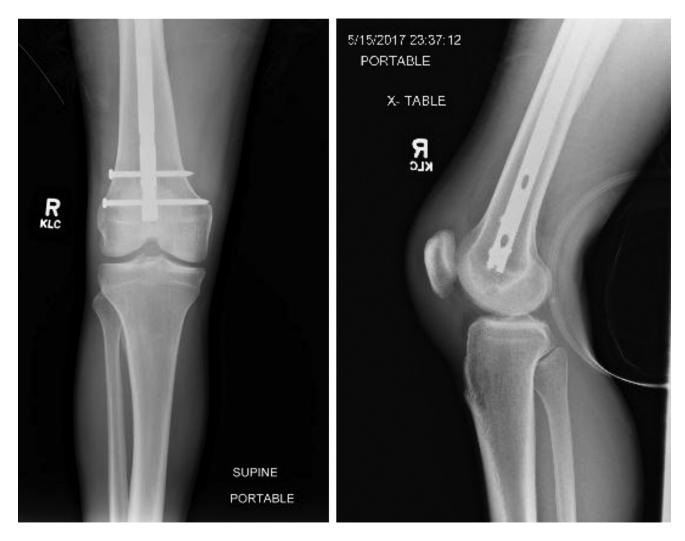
Right knee radiographs on presentation. AP view is unremarkable apart from partial visualization of intramedullary nailing hardware from remote femur fracture (a). Lateral view demonstrates soft tissue thickening in the region of the patellar tendon and a small joint effusion (b).
